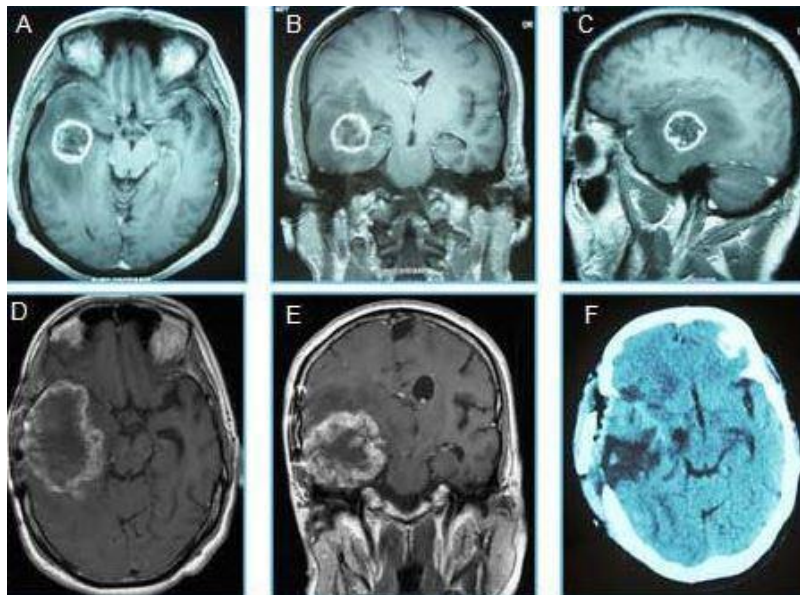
A: axial, B: Coronal and D: sagittal MRI images showed a Right temporal process corresponded to a glioblastoma. D: Axial and E: Coronal MRI image of a secondary gliosarcoma, at the same location of the previously treated GBM. F: axial CT, performed after the total resection of the gliosarcoma
